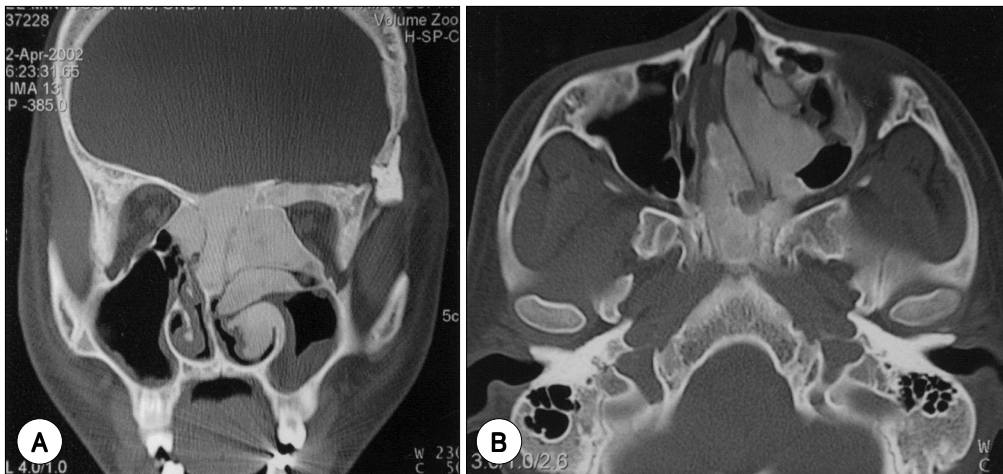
Coronal (A) and axial (B) CT scan of paranasal sinus in postoperative 1 years 8months : There is no interval change (ground glass appearance).
